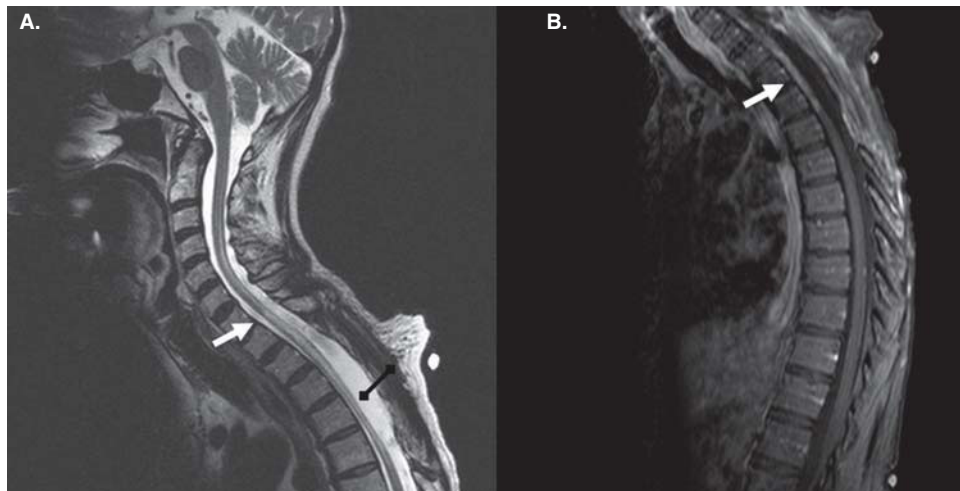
Case 1, MRI of cervical and upper thoracic spine. (A) T2-weighted sagittal view showed extensive increased signal in the cord extending from C4 level inferiorly, involving both the central cord and dorsal cord at some levels and dorsal cord at others. The thoracic cord showed signal abnormality extending from T1 (*white arrow*) to T6, and a large cyst (*black diamondhead arrow*) consistent with an intradural arachnoid cyst from T2 to T5 causing mass effect on the cord. (B) T1-weighted sagittal view postcontrast showed corresponding abnormal enhancement within the thoracic cord (*white arrow*).
